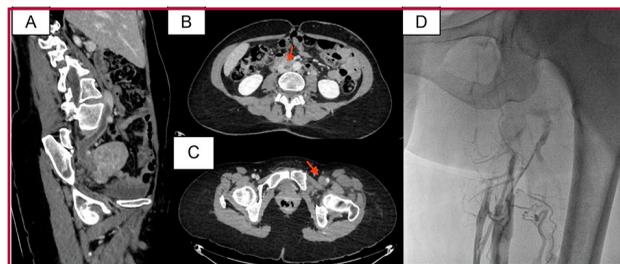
A: Computed tomography scan of the abdomen, parasagittal section, showing thrombosis of the inferior vena cava extending into the iliac vein. B-C: Computed tomography scan of the abdomen, axial sections, showing venous thrombosis of the left venous axis (red arrows indicate the areas of thrombosis). D: Venography of the left lower extremity confirming vascular occlusion extending from the proximal segment of the superficial femoral vein to the inferior vena cava, with highly developed collateral circulation and intraluminal filling defect suggestive of recent thrombus
